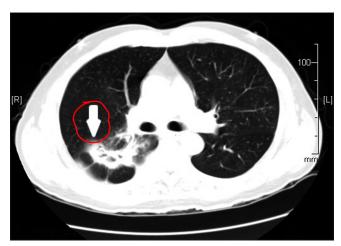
Computed tomography chest lung parenchymal window shows parenchymal consolidation in the right lung related to hemoptysis (white arrow)
